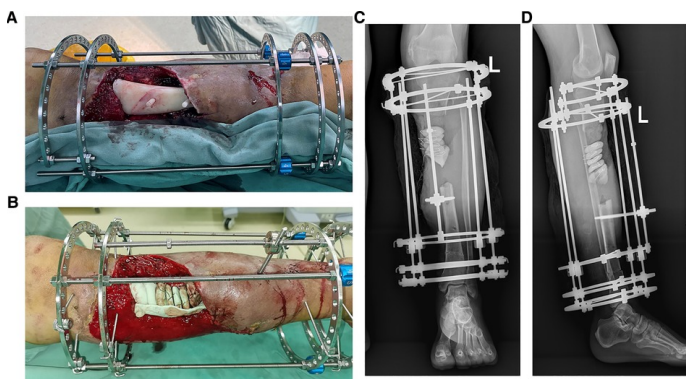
Intraoperative patient-specific instrument placement and postoperative X-rays in case 1 using Ilizarov distraction osteogenesis. (A) PSI maintains fracture alignment; (B) pie-shaped
